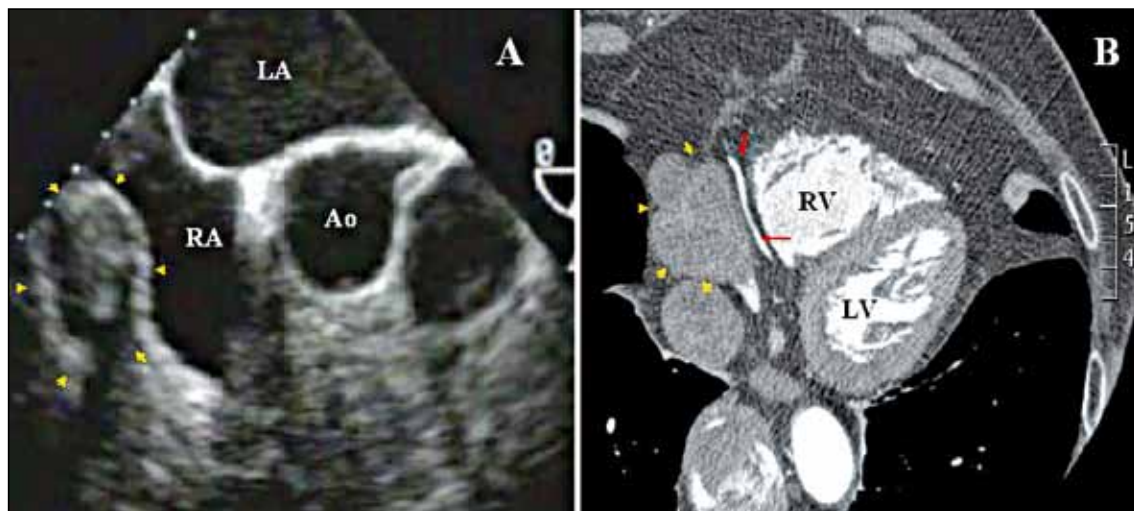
A transesophageal echocardiogram reveals a right para-cardiac mass apparently not infiltrating the cardiac wall (Panel A, yellow arrows); the computed tomography scan confirms the anatomical position of the mass (Panel B, yellow arrows) and its spatial relationship with the right coronary artery (Panel B, red arrows).
